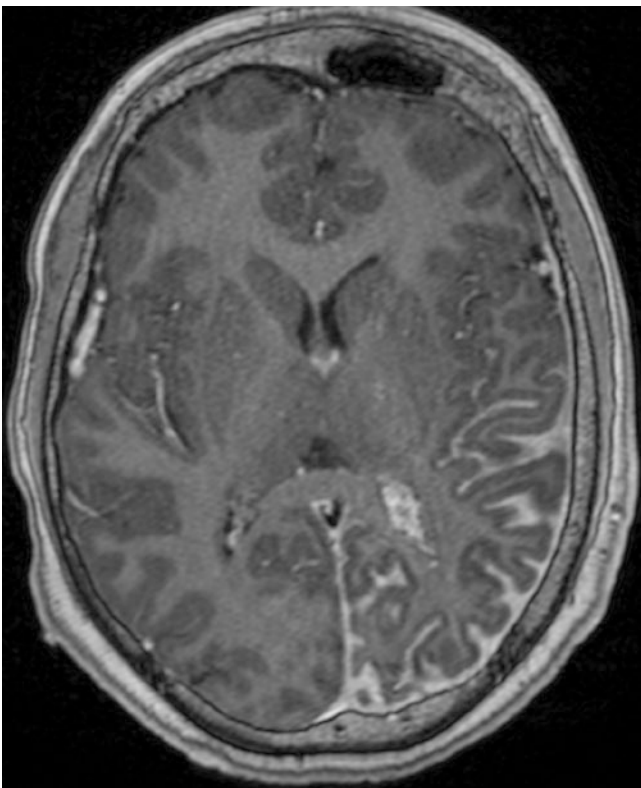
Sturge-Weber syndrome. Axial post-contrast T1-weighted MR image demonstrates florid pial enhancement in the left parieto-occipital region. The left lateral ventricle choroid plexus is enlarged and enhances avidly
